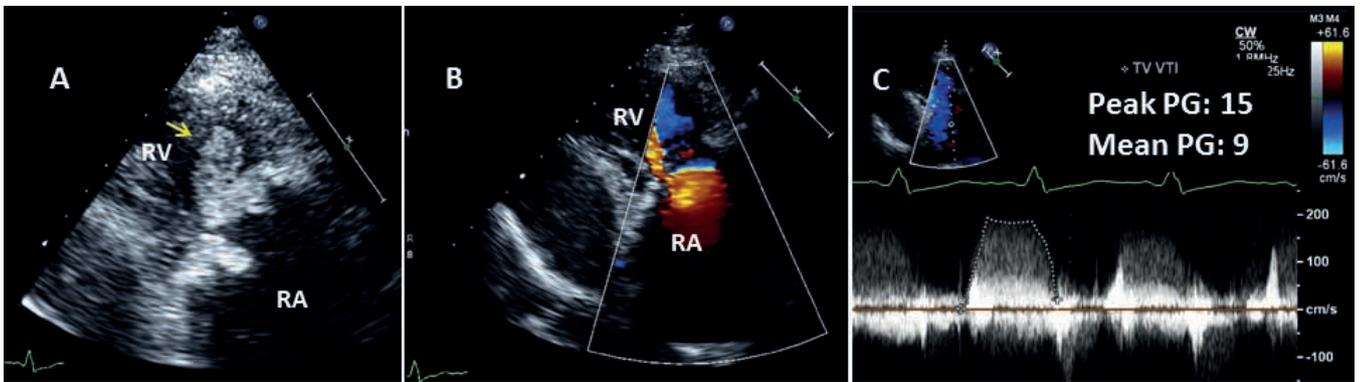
Bioprosthetic tricuspid valve stenosis and mass. Transthoracic echocardiographic images in the right ventricular outflow view demonstrating a bioprosthetic tricuspid valve with thickened leaflets along with a mobile mass present on the leaflets (arrow) suggestive of a vegetation or thrombus (A). (B) Color Doppler demonstrates turbulent diastolic flow across the valve. (C) Spectral Doppler confirms a peak E velocity of 2 m/s, a peak pressure gradient of 15 mm Hg, and a mean pressure gradient of 9 mm Hg consistent with severe stenosis. RA, right atrium; RV, right ventricle.
